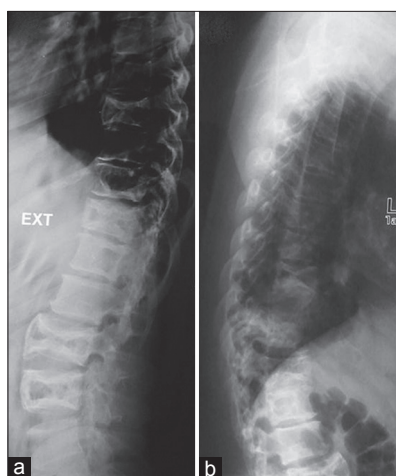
Radiograph of case one showing multiple osteolytic and expansile lesions in the spine
